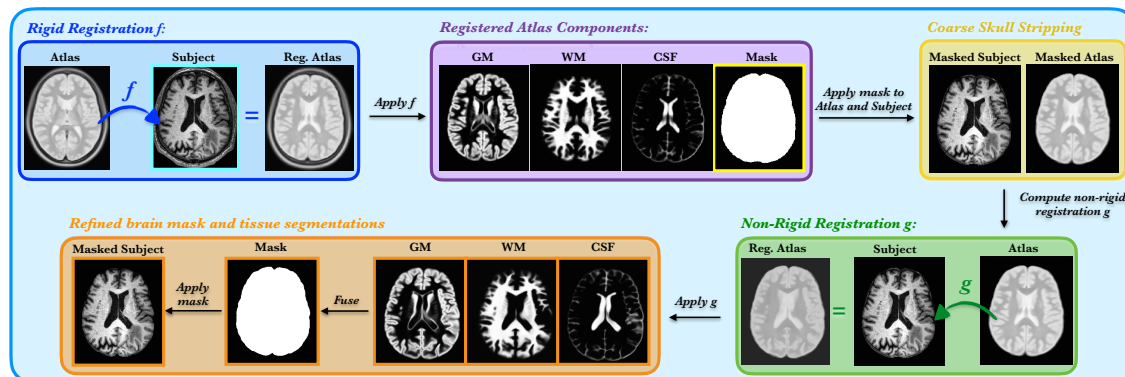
An overview of the S3 algorithm. The method takes as input the head MRI scan (marked by the cyan frame) and as output provides brain mask, skull-stripped input MRI scan, and the brain tissue segmentations (shown in the orange box).
